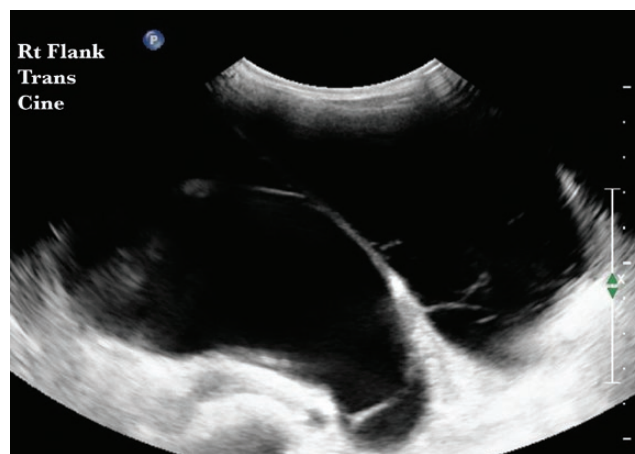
Abdominal ultrasound showing CSF pseudocyst.
